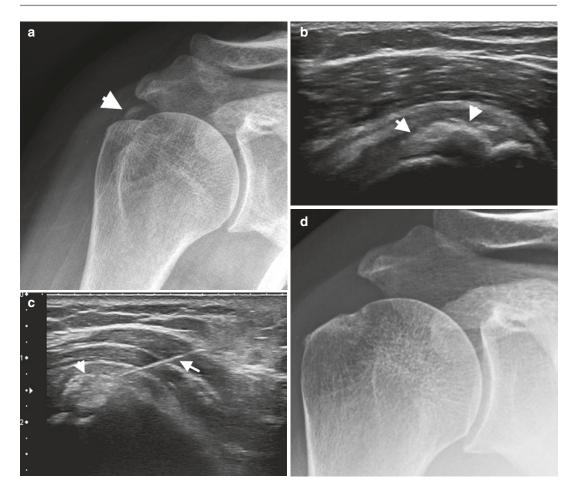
A 28-year-old female with calcific tendinopathy of the supraspinatus tendon with persistent pain and limited range of motion for 1 year. (a) AP radiograph demonstrates calcification of the supraspinatus tendon (*arrowhead*). (b) Longitudinal ultrasound with hyperechoic calcific deposit corresponding to radiograph (*arrowheads*), patient
